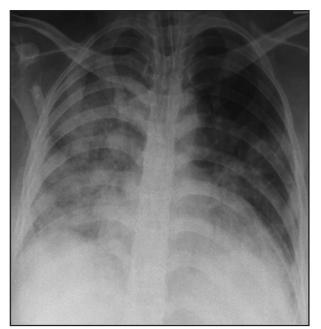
Chest radiograph on day 3 of illness showed worsening opacities over bilateral lung fields.
